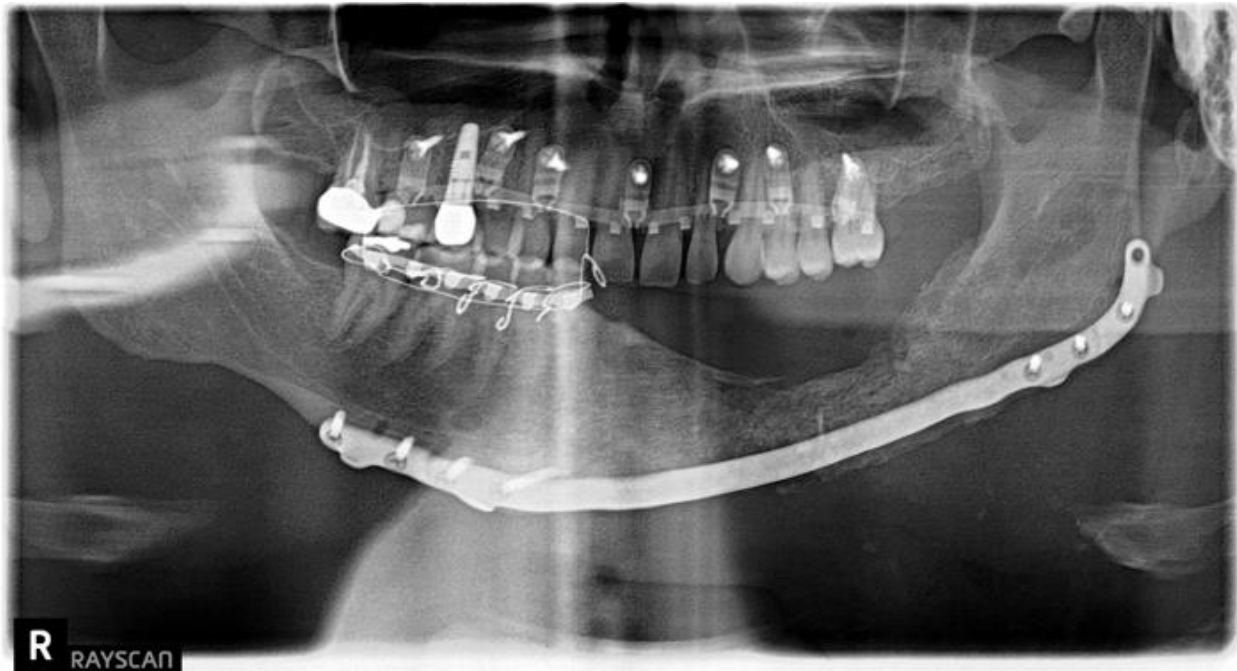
Post-operative panoramic radiograph following final AICBG.
